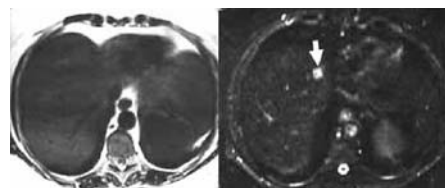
A hepatic metastases was not depicted on a T2-weighted FSE (TR 4100, TEef 102) image, left, but is well visualized (arrow) on a STIR image (TR 3000, TE 60, TI 160), right.
